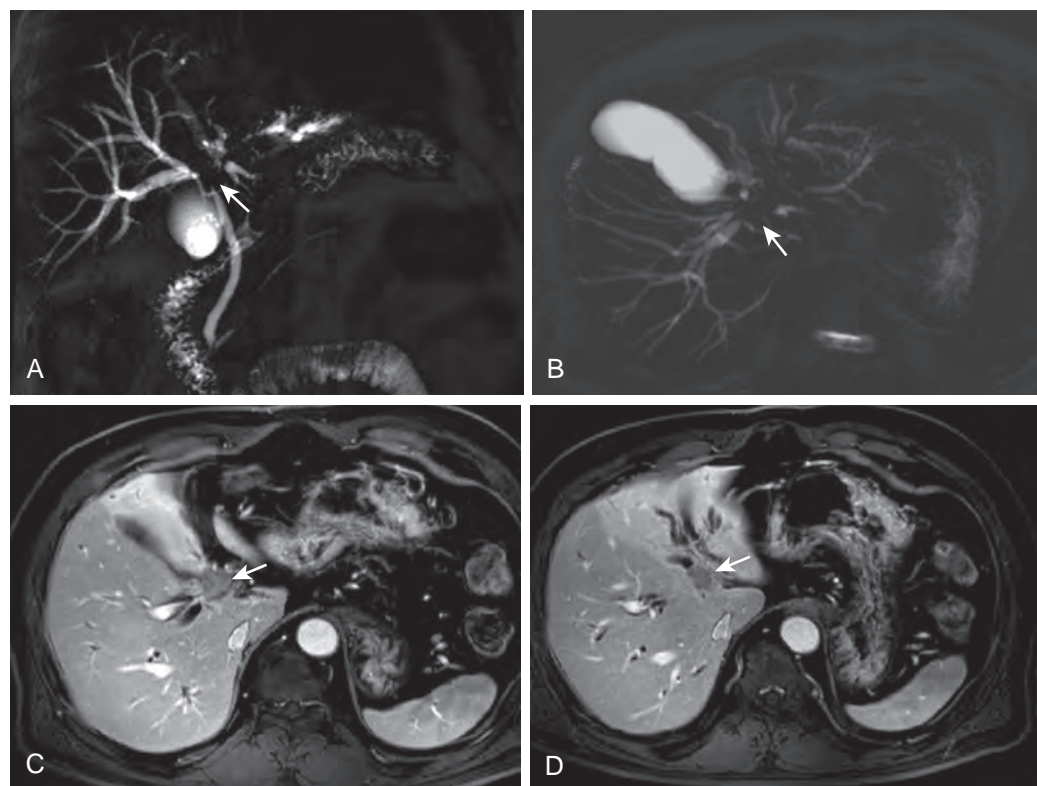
Comprehensive evaluation of hilar cholangiocarcinoma by MRI with MR cholangiography for surgical resectability. A and B. Coronal and axial thick-slab single-shot MR cholangiograms demonstrate hilar cholangiocarcinoma involving both secondary biliary confluences with upstream ductal dilation. Note that segmental intrahepatic ducts of the left lobe are separated by the tumor (arrow). C and D. Postcontrast T1-weighted MR images demonstrate a periductal infiltrating hilar cholangiocarcinoma involving ductal bifurcation area and both main hepatic ducts (arrow). The mass (arrow) shows hypoenhancement compared with adjacent liver parenchyma.
